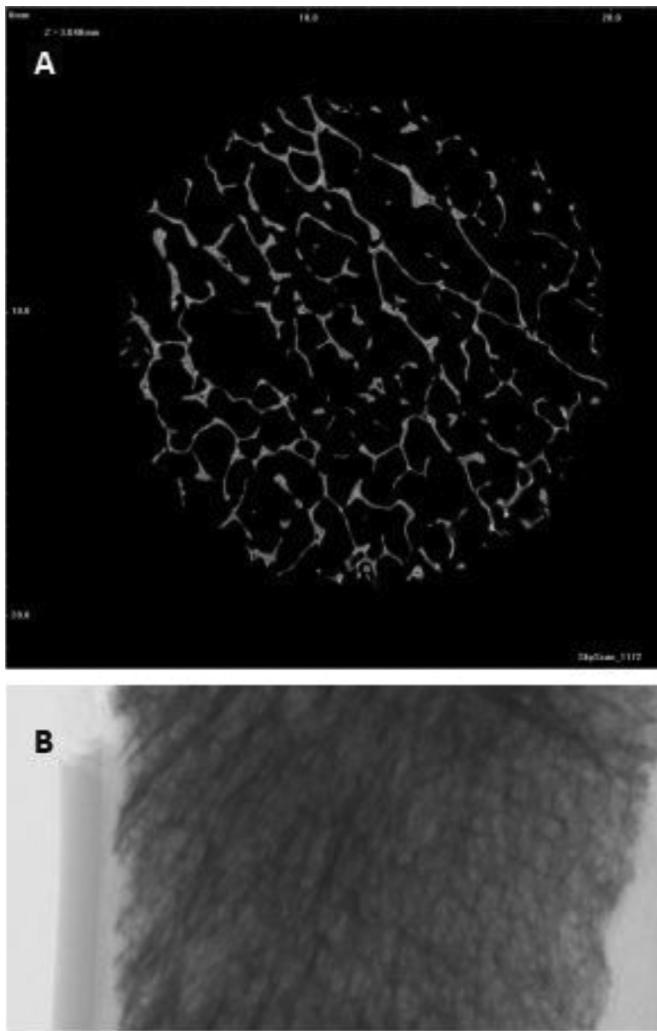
A. Micro-computed tomography axial cut of a femoral head in a patient who suffered a femoral neck fracture. B. The selected region of interest on a coronal view.
